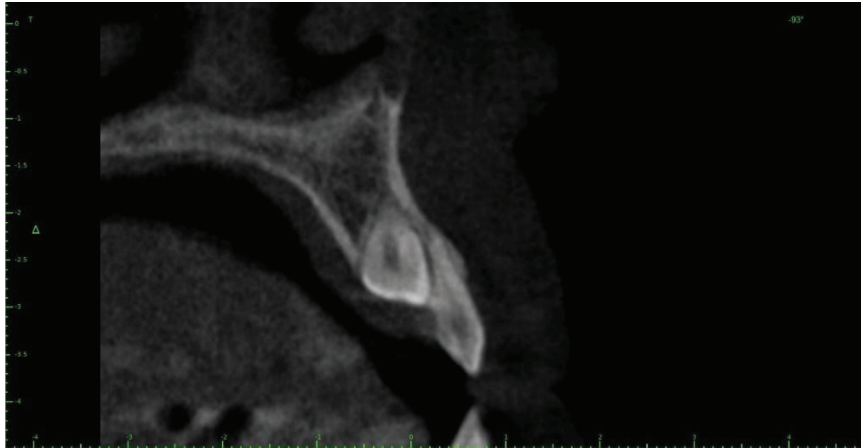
Cone beam computed tomography (CBCT) scan showing resorption on the palatal surface of the upper lateral incisor.
